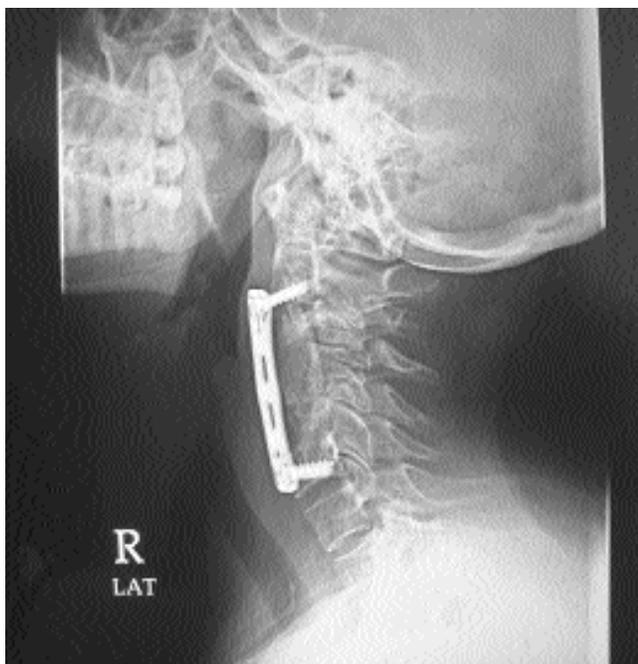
X-ray spine after en bloc resection and anterior cervical fixation.
